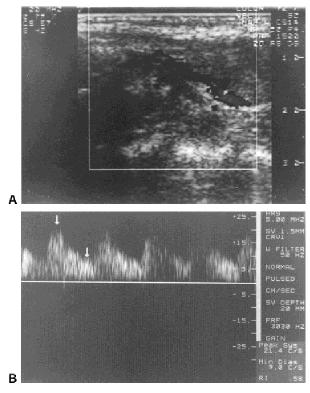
(A) Longitudinal color Doppler sonogram of the normal left superior thyroid artery and upper pole thyroid tissue of a patient; (B) respective normal peak velocity measurement in the superior thyroid artery.
